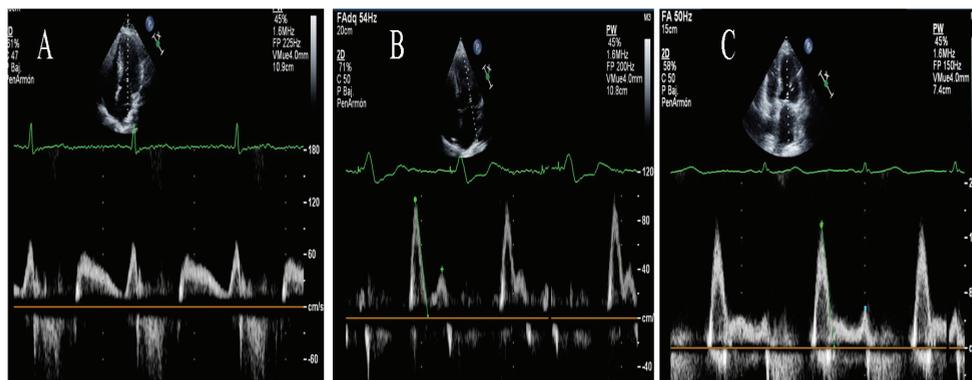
Pulsed Doppler mitral filling flow showing: A) Impaired relaxation pattern, B) Pseudonormal pattern C) Restrictive pattern
